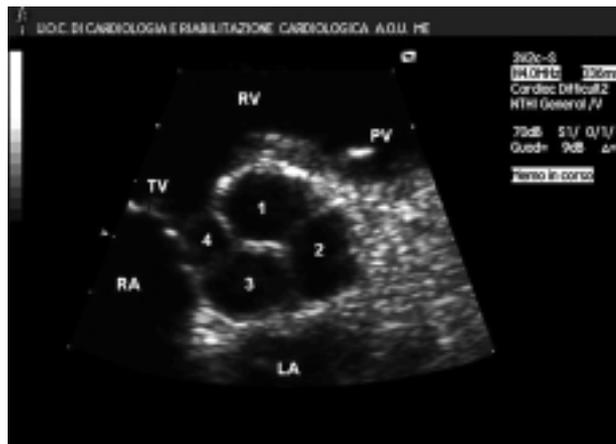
Parasternal short-axis view of the quadricuspid aortic valve in diastole showing four unequal-sized cusps. LA = left atrium; PV = pulmonary valve; RA = right atrium; RV = right ventricle; TV = tricuspid valve.
